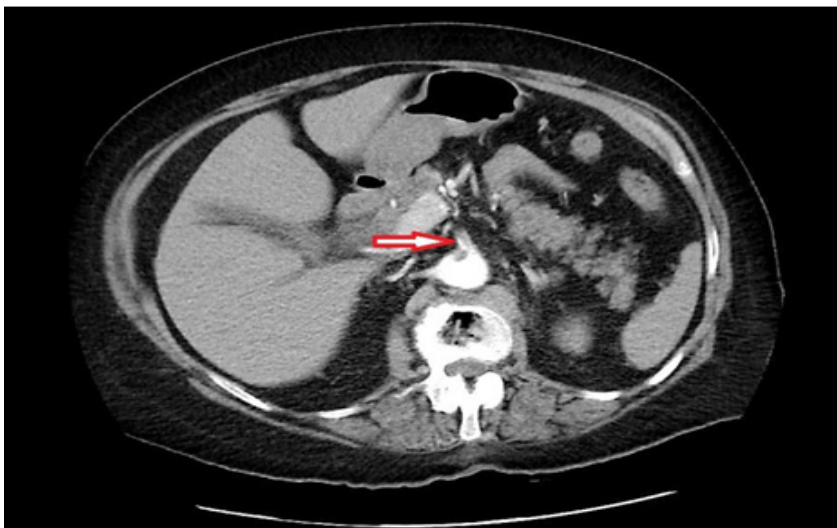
CT abdominal scan demonstrates occlusion of the superior mesenteric artery (red arrow).
